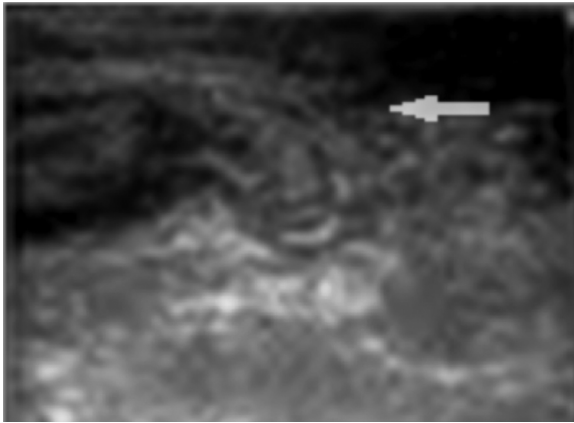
Ultrasonographic image demonstrating a lesion in the right hemi-scrotum, with cystic compounds, which coils around the spermatic cord (arrow).
